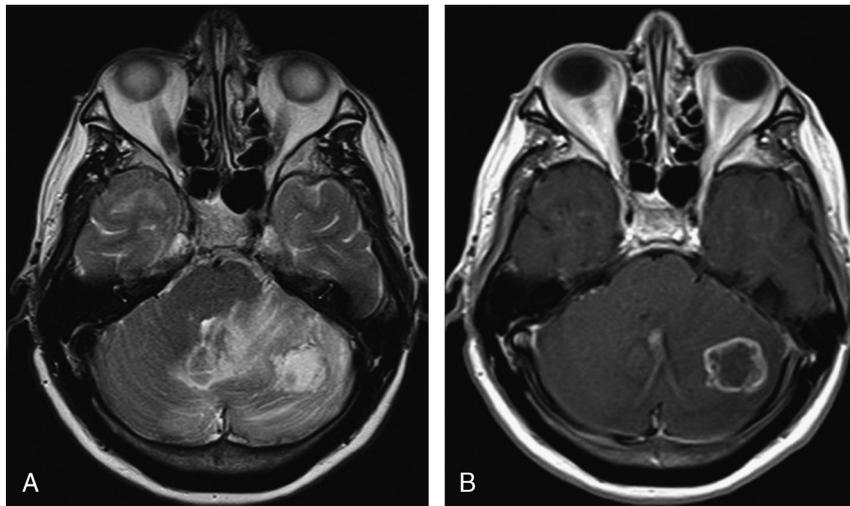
A, Axial T2-weighted image shows a hyperintense mass with peripheral edema in the left cerebellar lobe. B, Gadolinium-enhanced T1-weighted image showing ring enhancement of the lesion.
